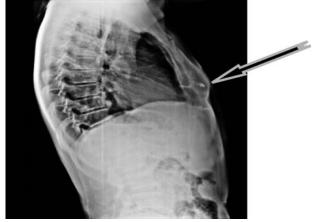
Radiograph of the sternum (lateral view) showing the erosion of the anterior sternal table (arrow), and the increased overlying soft-tissue density.
